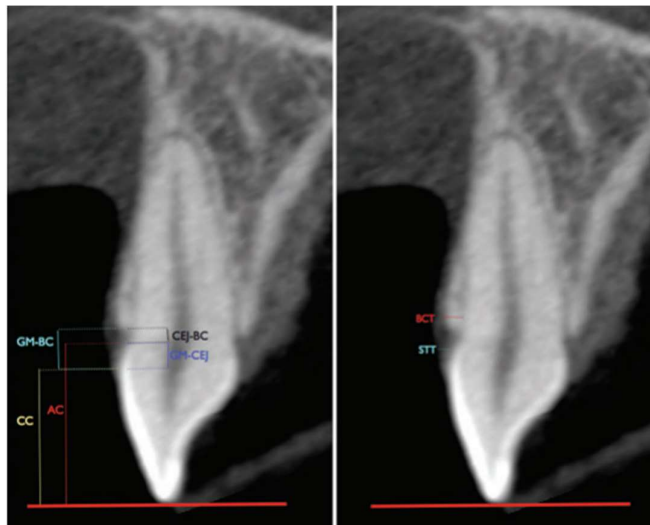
CBCT for Altered passive eruption diagnostic and aesthetic crown lengthening treatment plan (Batista et al., 2012)
